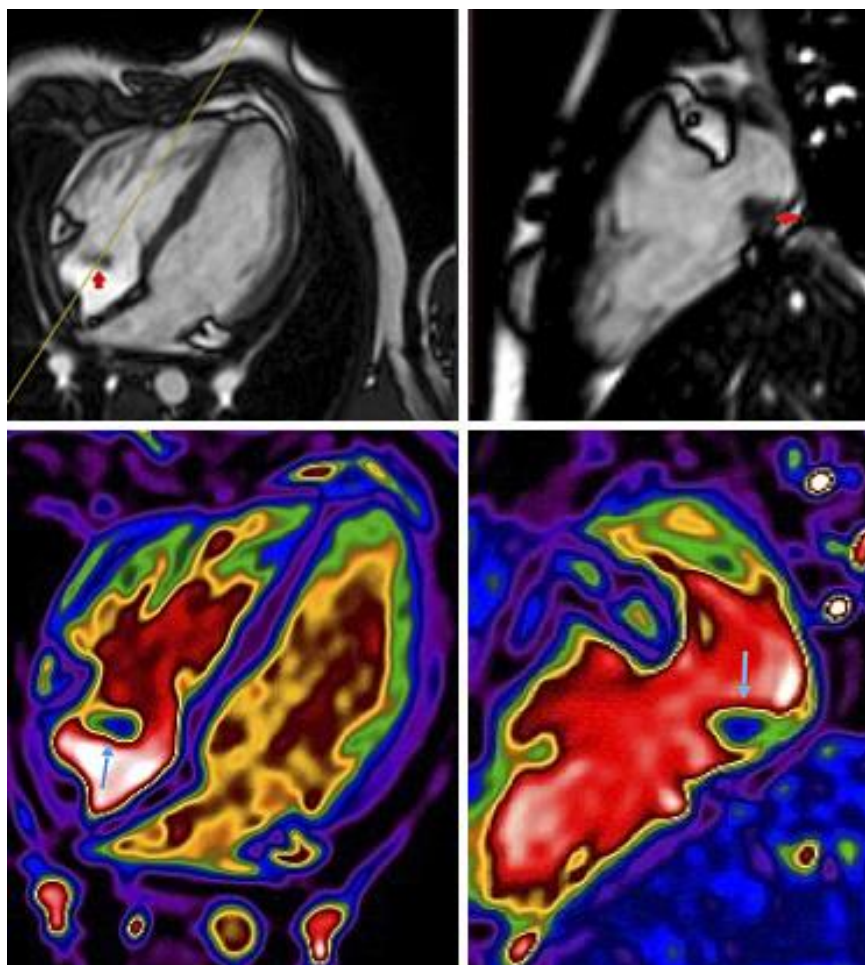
MRI showing the immobile thrombus attached to the anterior right atrium wall
